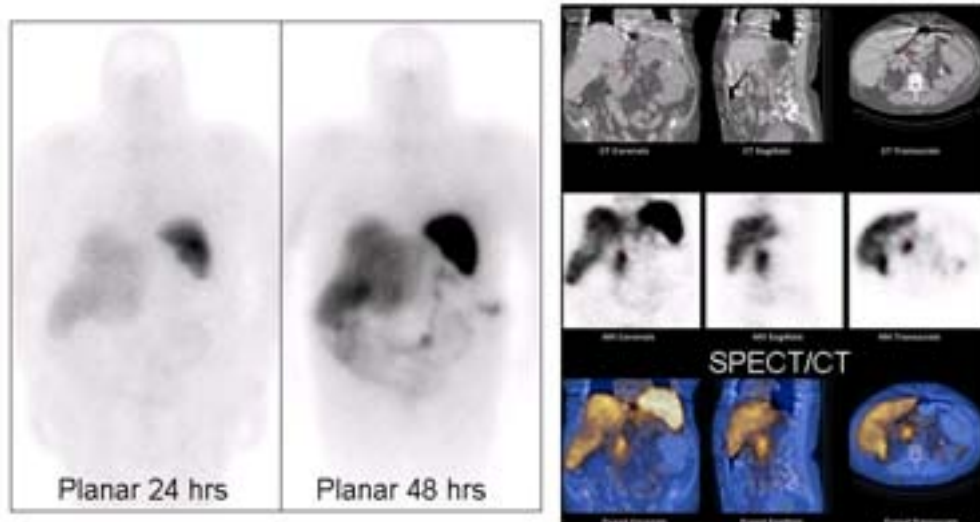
^{111}In -octreotide SPECT/CT in duodenal carcinoid. A 56 year old woman with duodenal carcinoid diagnosed following biopsy of a duodenal ulcer was referred for defining extent of disease prior to treatment planning. Whole body planar scans performed at 24 and 48 h after tracer injection are normal. SPECT demonstrates a small focus of abnormal tracer activity in the right mid-abdomen, localized by SPECT/CT fused images to the duodenum, consistent with the known primary tumour. No additional sites of abnormal tracer activity are seen. The patient was referred for surgery.
